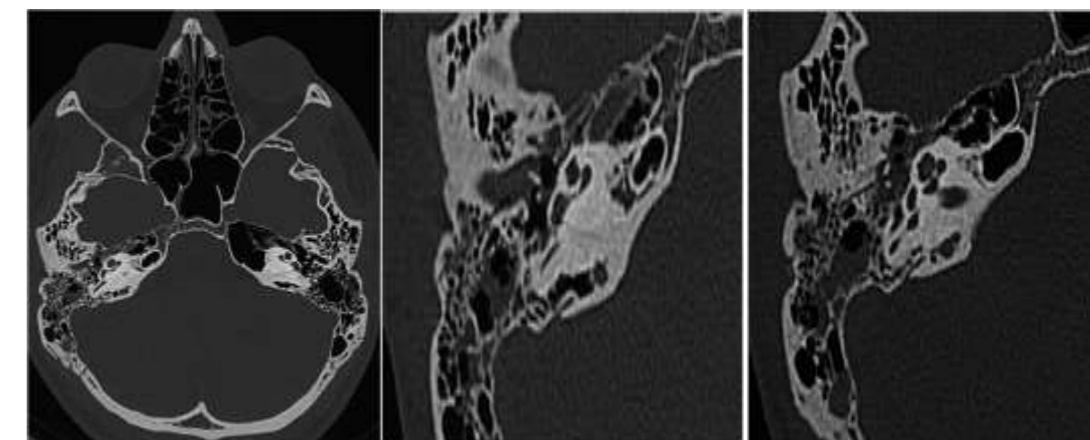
(Left) Axial CT brain bone window showing opacification of right mastoid air cells. (Middle and Right) Magnified views of right temporal axial CT bone window demonstrates right longitudinal temporal bone fracture sparing the otic capsule associated with incudomalleolar joint separation and right hemotympanum in a 26-year-old patient presented with right otorrhagia post road traffic accident.
